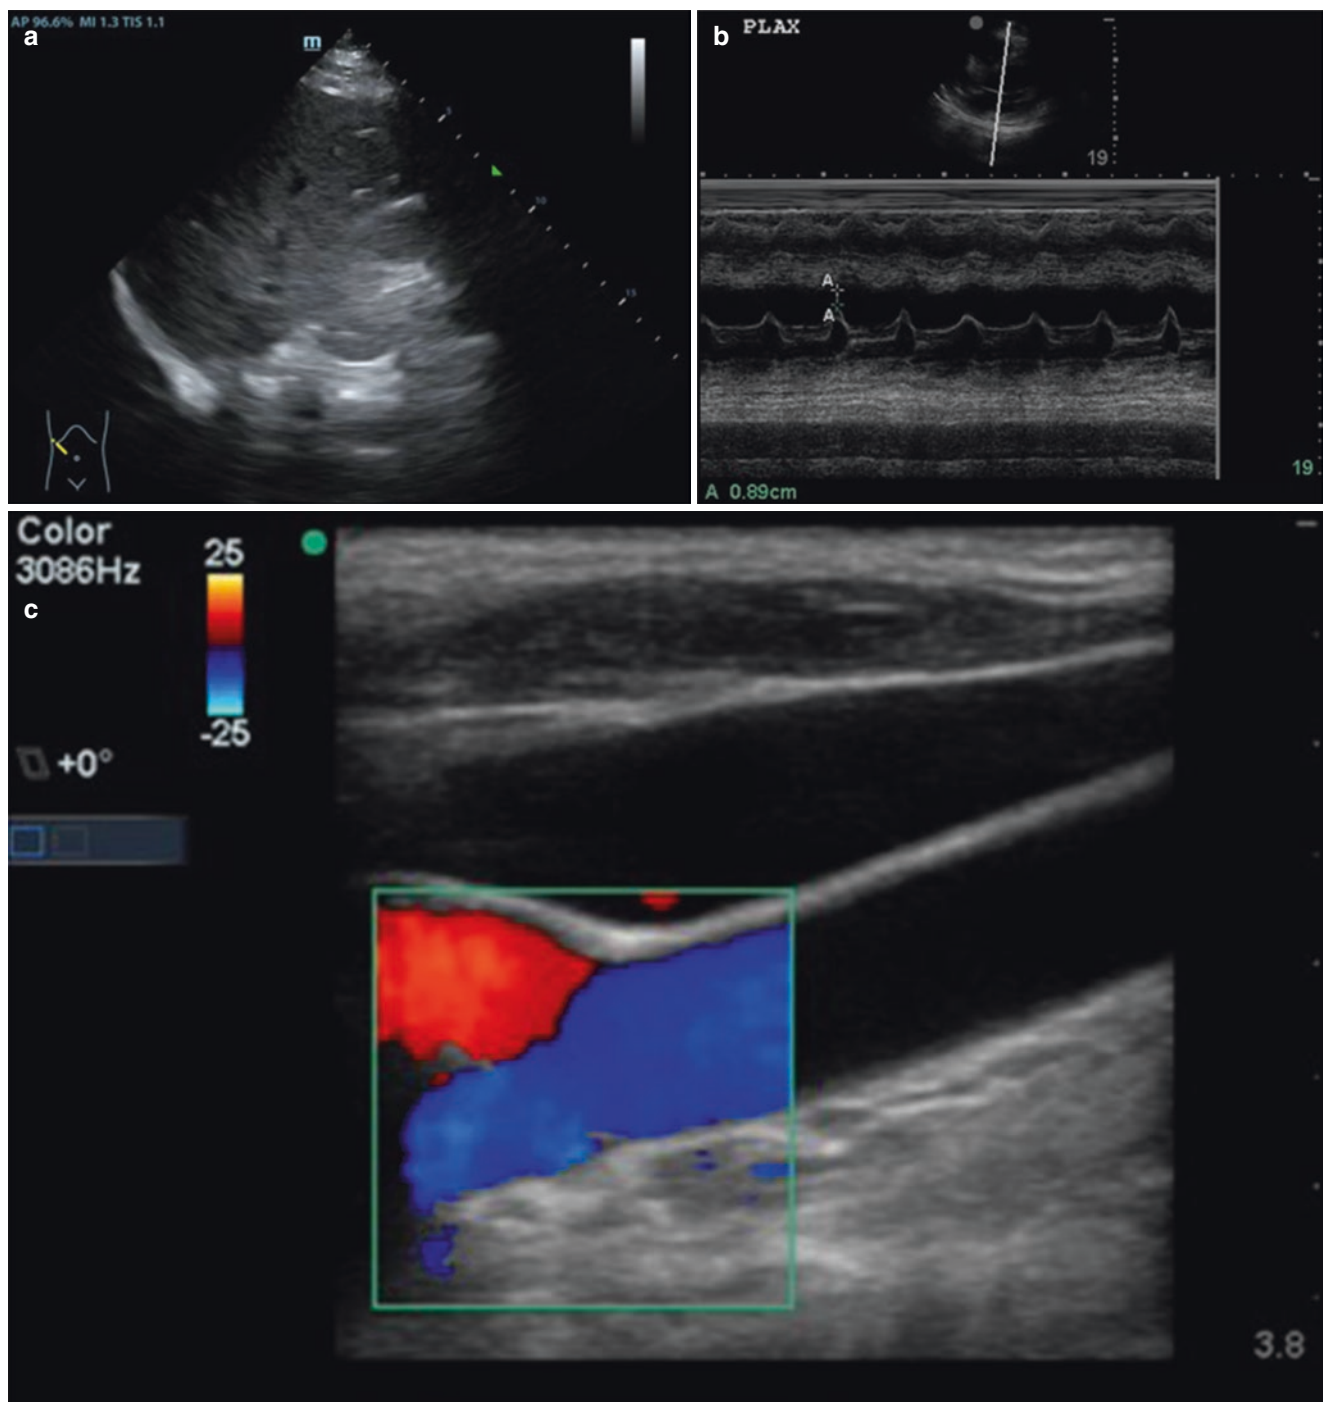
Ultrasound imaging modes. (a) B-mode, also called 2D mode on some machines, produces 2D image of echo-producing interfaces of underlying objects. (b) M-mode, “motion mode,” demonstrates movement of structures over time. All cardiac structures through which the solid white line passes in the top B-mode image are graphed over
